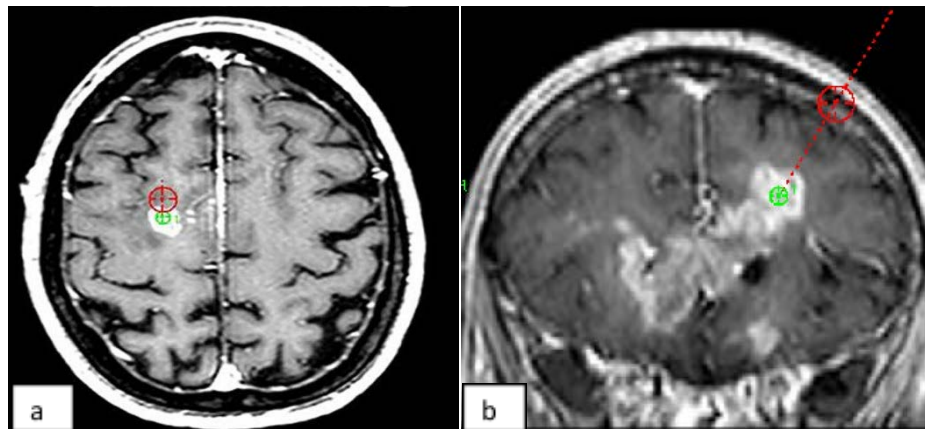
Types of cerebral gliomas selected for the stereotactic biopsy (T1 MRI with snapshot contrast, selected during the preoperator time) – Sp. CL. “Bagdasar-Arseni”
